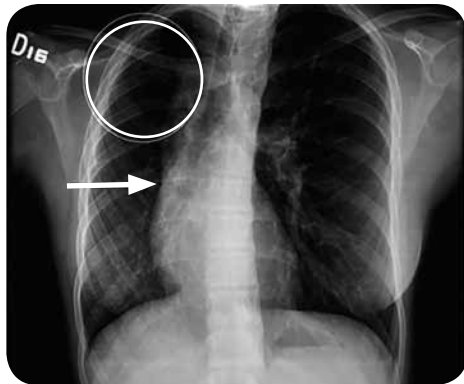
Chest X-ray PA. In the right hemithorax, the inferior interlobar artery (arrow) is missing; there is a marked decrease in the distal vascular weave, mainly in the upper lobe (circle); the lung volume is decreased compared to the contralateral hemithorax and the cardiomedastinum, displaced to the right side.
